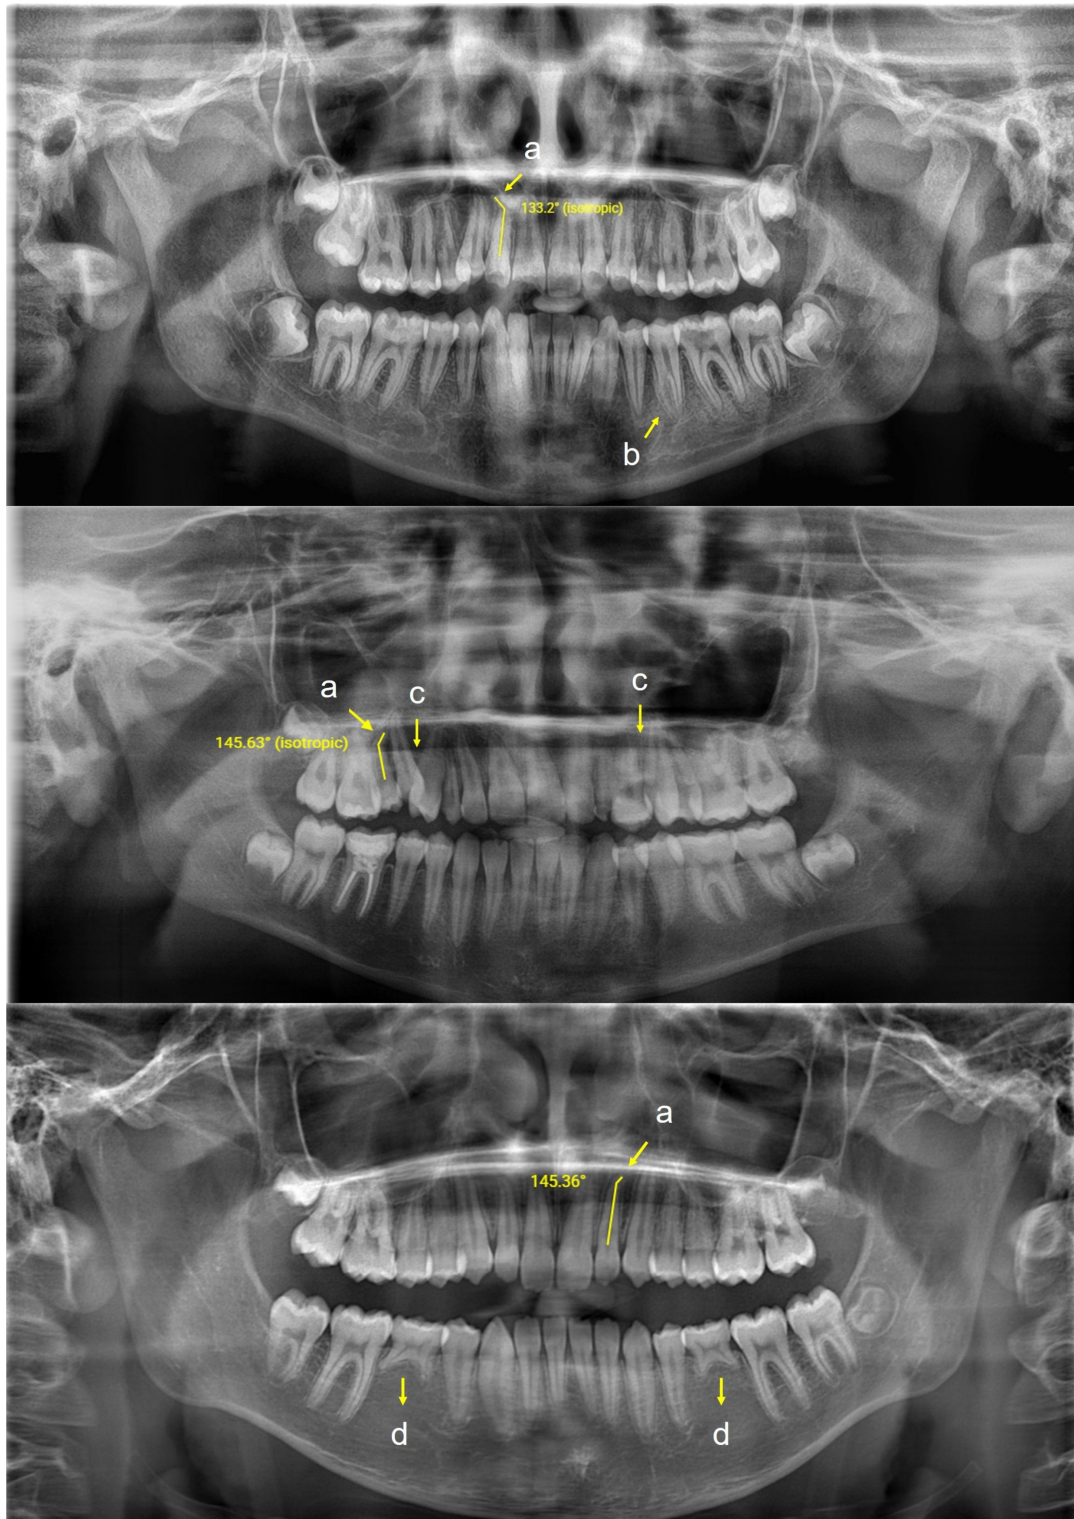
Representative diagnosed anomalies are indicated by yellow arrows on the panoramic radiographs; a: dilaceration of tooth, b: supernumerary root and taurodontism, c: transposition, d: hypodontia
